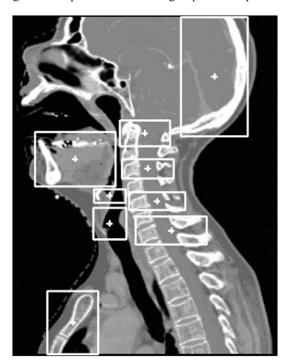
Sagittal view of the planning computed tomograph with 9 regions of interest on bony structures (cervical vertebrae 1, 3, 5, and 7, lower jaw, hyoid bone, larynx, jugular notch, and skull).
